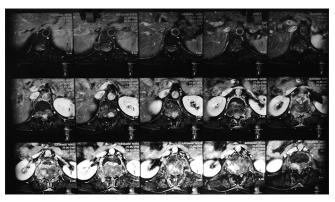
MRI LS Spine axial section showing the invasive nature of the lesion
